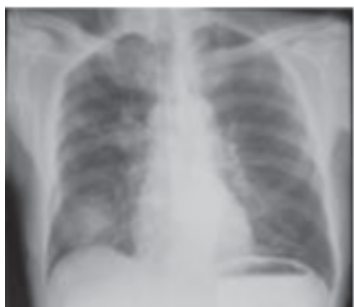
PA chest X-ray with pneumonic shadow.
